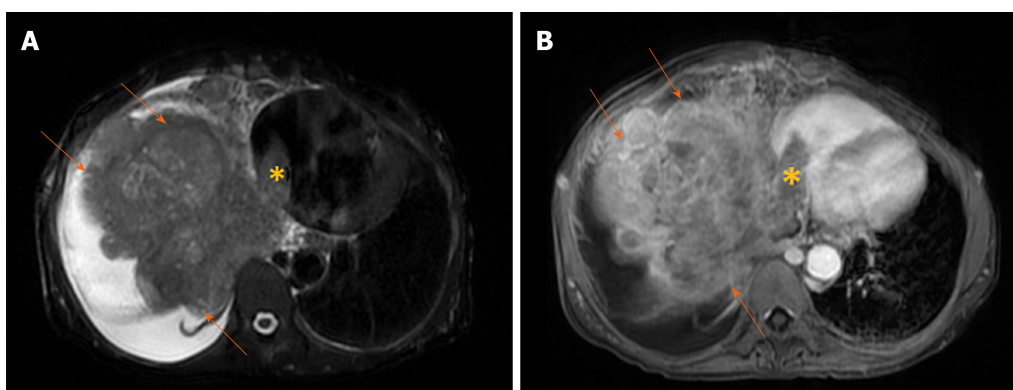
Massive hepatocellular carcinoma in 69-year old woman with cirrhosis. A: Axial T2-weighted image shows a large mass (arrows) predominantly located in right liver lobe with infiltration of vena cava and tumor thrombus seen in left atrium (asterisk); B: Axial image in portal venous phase shows washout in hepatocellular carcinoma (arrows) and thrombus (asterisk) in left atrium.
